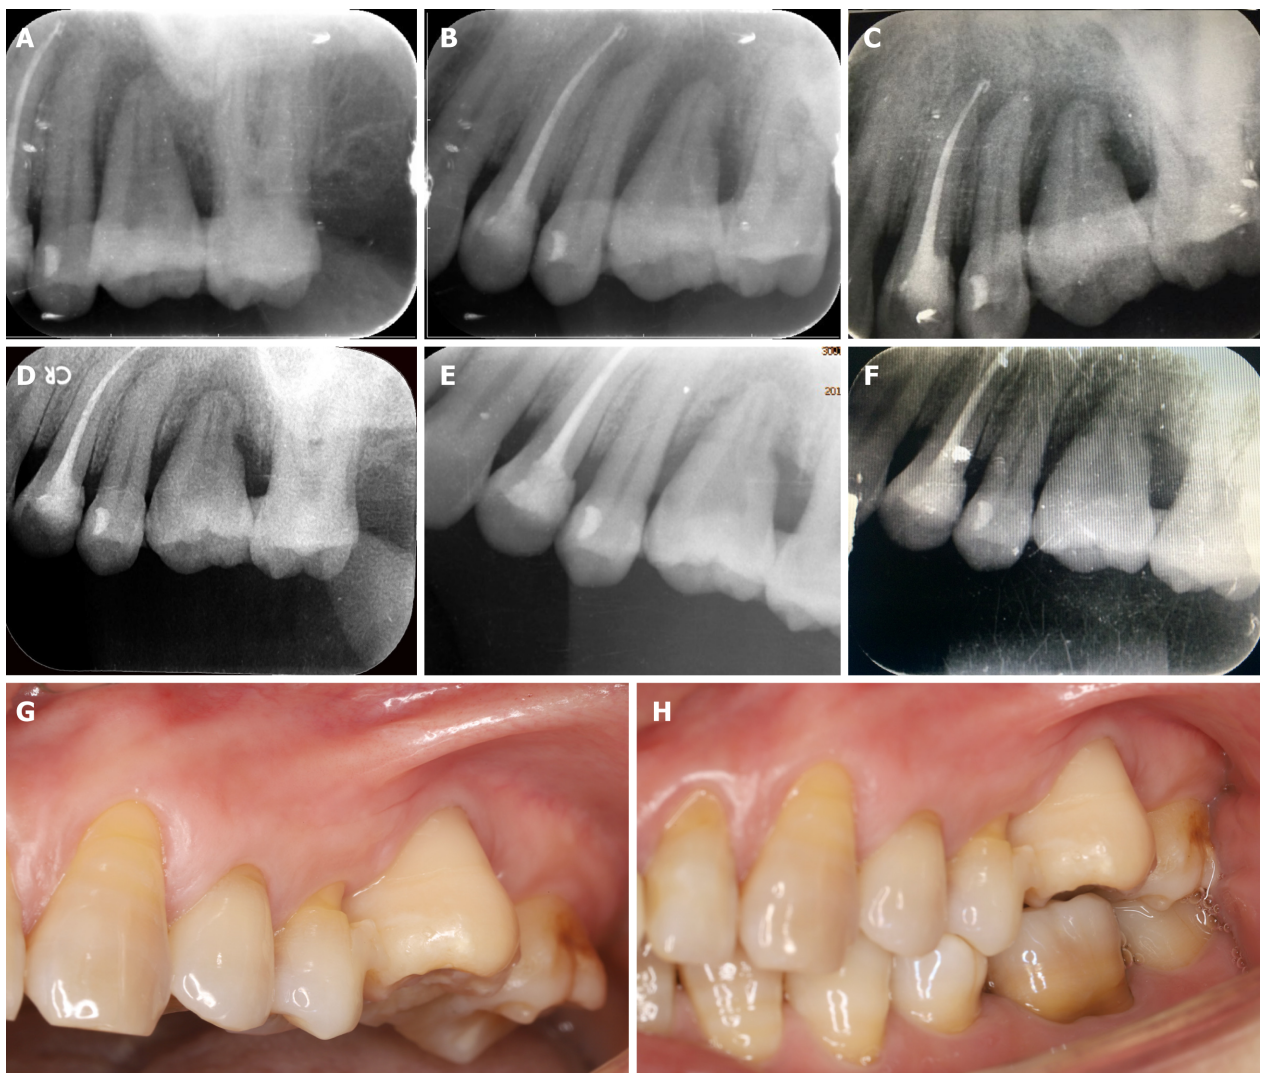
Periapical radiographs of the transplanted tooth after surgery. A: One day after transplantation; B: One week after transplantation; C: One month after transplantation, inflammatory resorption and replacement resorption were progressing; D: Two months after transplantation; E: Three months after transplantation; F: Four months after transplantation, inflammatory resorption and replacement resorption were stable, and there was no appearance of normal periodontal ligament up to this time; G and H: Photos showing the transplanted tooth four months after surgery.
